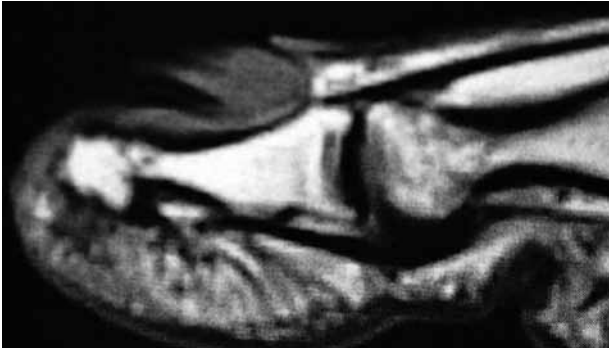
MRI of the nail unit. T1. Sagittal view: Finger-like projections. © Dr E. Terqueux, Montpellier, France
